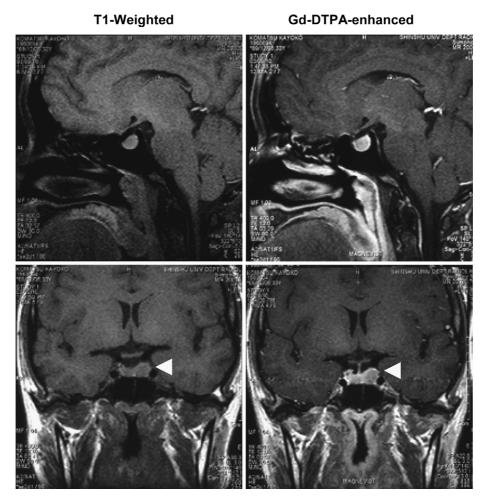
Pituitary MRI. Pituitary tumor is noted (arrowheads).
